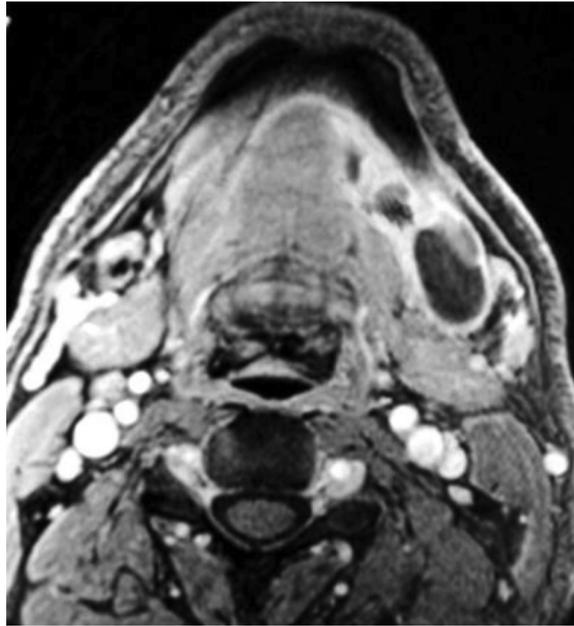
CT showing the fluid cavity in left sublingual space extending to submandibular space.
